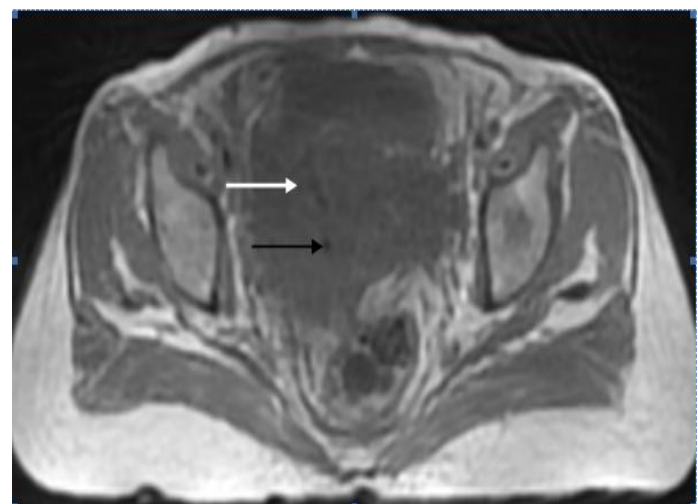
T1 W axial MRI image showing isointense lesion in pelvis with multiple internal hypointense foci.
